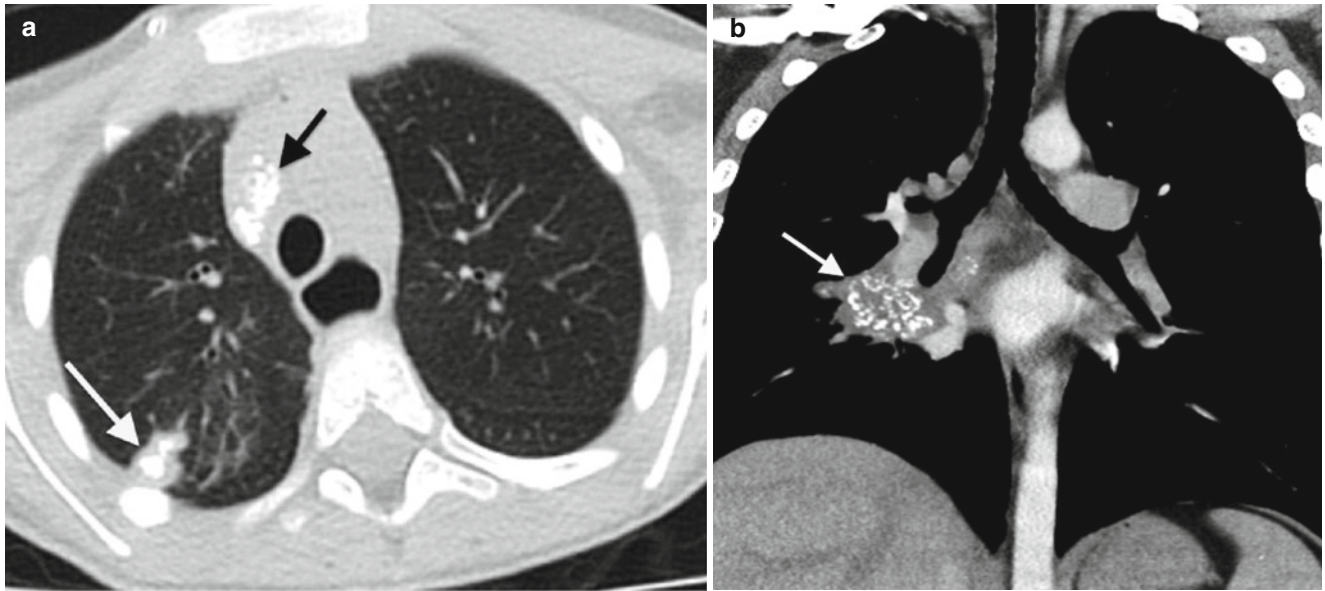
Histoplasmosis in two different patients. Axial CT image of a 4-year-old boy (a) showing a calcified pulmonary nodule in the right upper lobe (*white arrow*) and calcified lymph nodes in the pretracheal region (*black arrow*). Coronal reconstructed CT image on a
